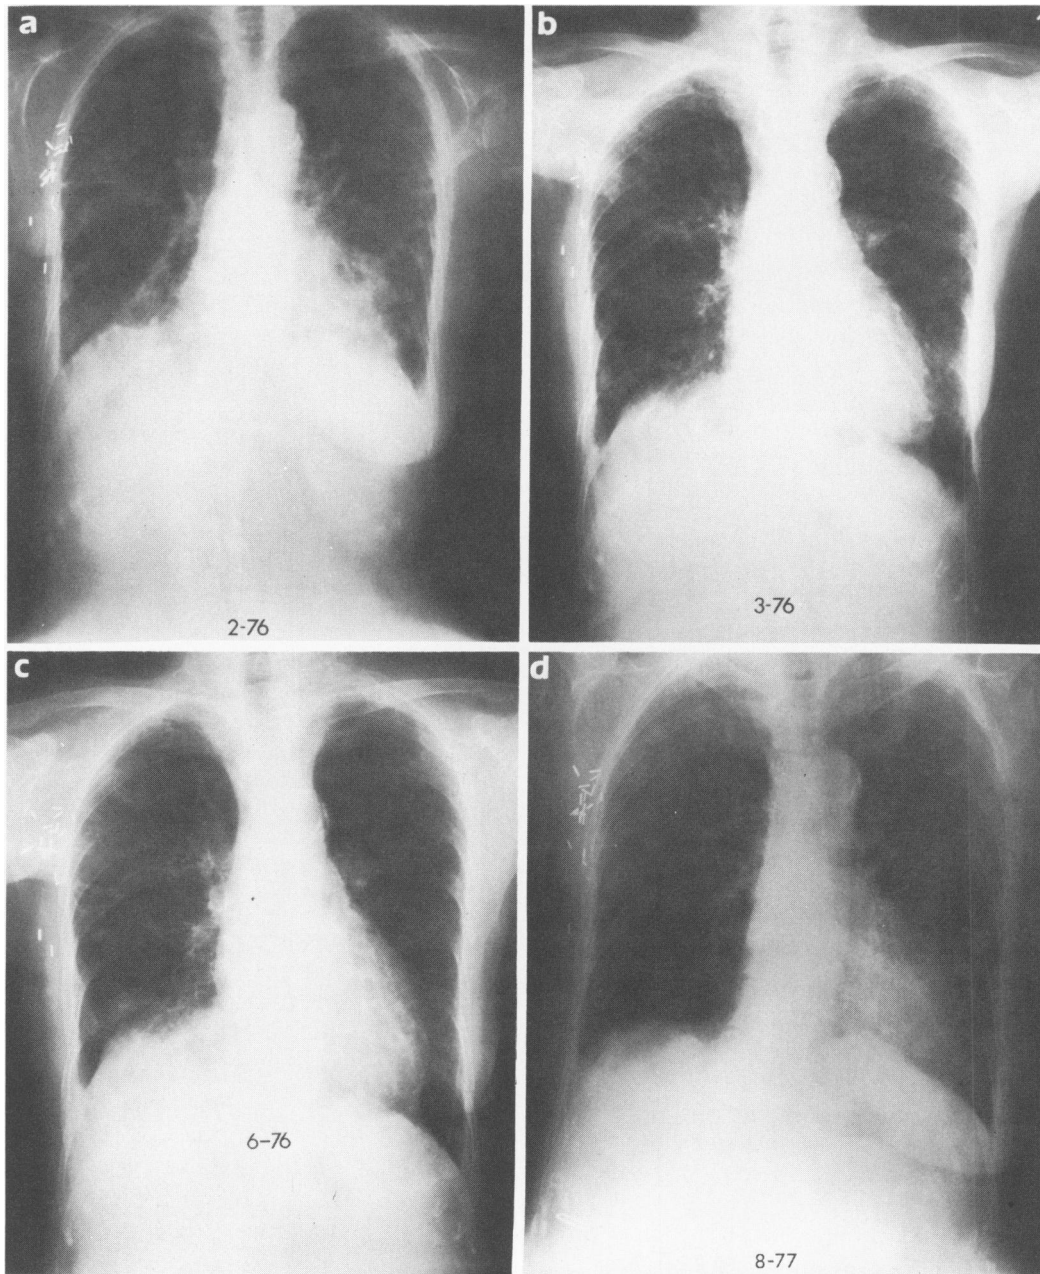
Chest roentgenographs of patient No. 35 prior to (a) and during (b-d) aminoglutethimide and dexamethasone therapy.
